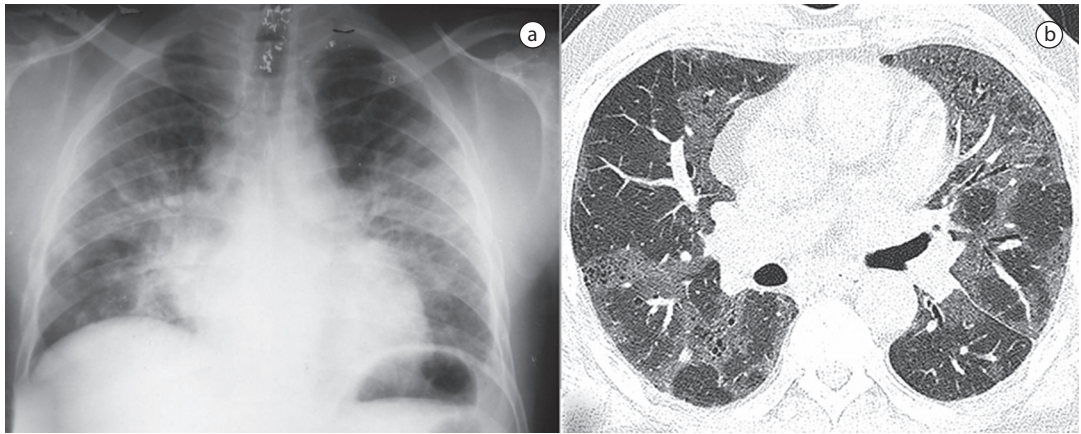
In a), chest X-ray revealing bilateral interstitial infiltrate (1996); in b), HRCT showing areas of ground-glass attenuation, traction bronchiectasis, and interposed cystic images (2006).
